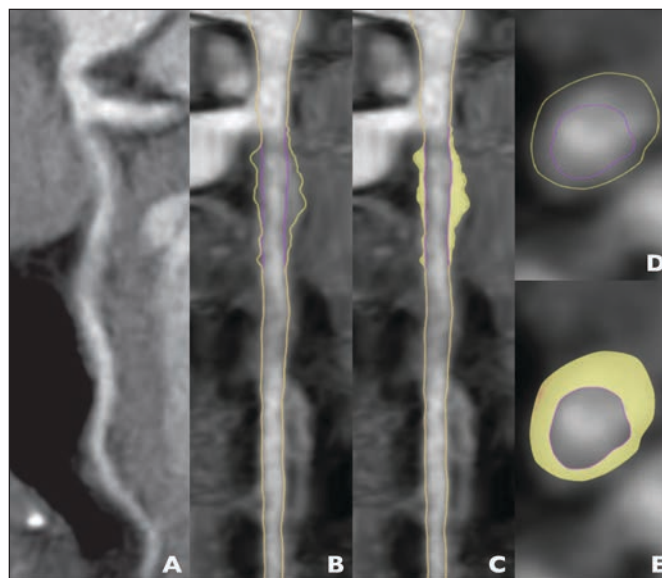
70-year-old patient who presented with unstable angina and underwent coronary CTA. Patient had coronary artery calcium score of 0. Patient had acute coronary syndrome develop 77 days after coronary CTA was performed. Coronary CTA identified lesion in proximal left anterior descending (LAD) artery, which was nonculprit lesion based on invasive coronary angiography.
